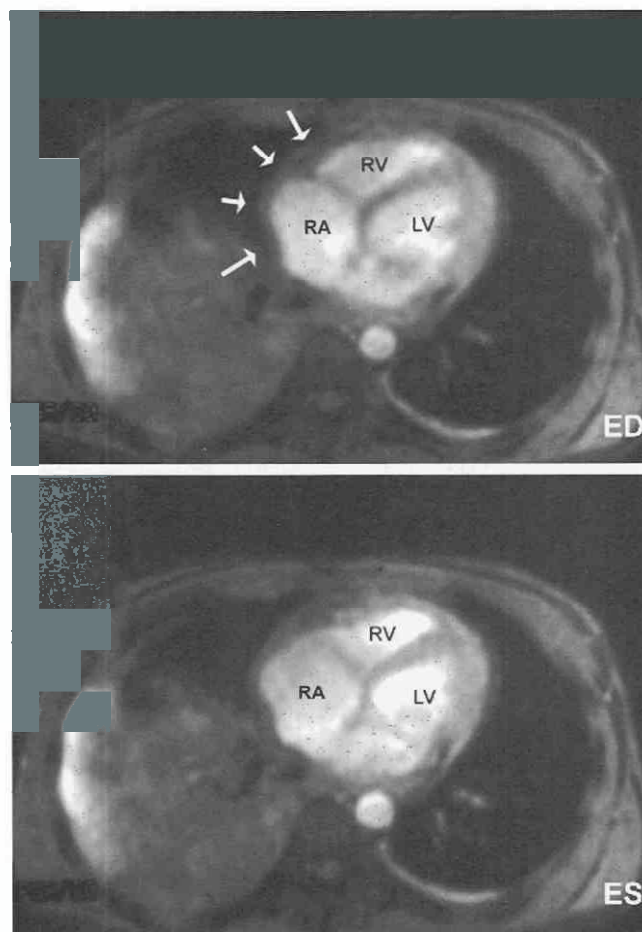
MR images obtained from a 23-year-old college student with shortness of breath. The upper gradient-echo acquisition obtained at ventricular end-diastole (ED) shows pericardial thickening increasing the distance between the cavity of the right atrium and the lateral aspect of the heart (*arrows*). The lower figure obtained at end-systole (ES) shows little change in the volume of the ventricles and a characteristic tubular appearance of the right ventricle (RV). Bilateral pleural effusion is evident. LV, left ventricle.
